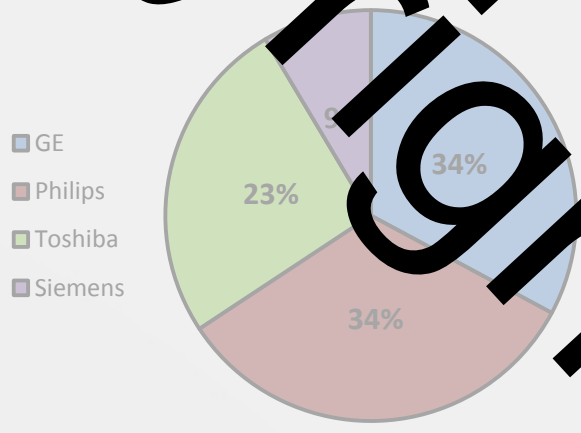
Distribution of the CT units among the four manufacturers
